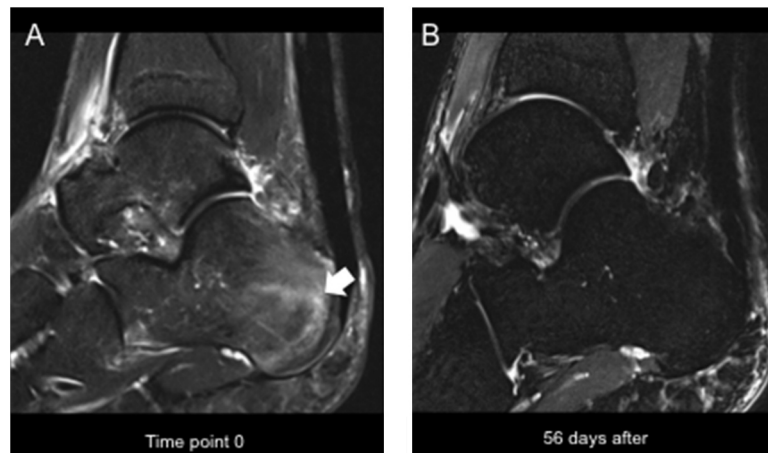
Athlete with a bone marrow oedema of the calcaneus. Case of a 33-year-old first league soccer player complaining about pain on the left hindfoot for already 345 days preventing the athlete from full training. MRI at first visit demonstrates an intense BMO of the posterior calcaneus as well as an Achilles tendinopathy (arrow). Follow-up imaging shows a decrease of the BMO after high dose vitamin D and bisphosphonate treatment combined with a significant reduction of pain (Please note: MRI was performed in two different external facilities. Thus, sequences are slightly different, but still comparable.). RTC was recorded at 194 days, indicating that late diagnosis and delayed treatment lead to a long absence time.
